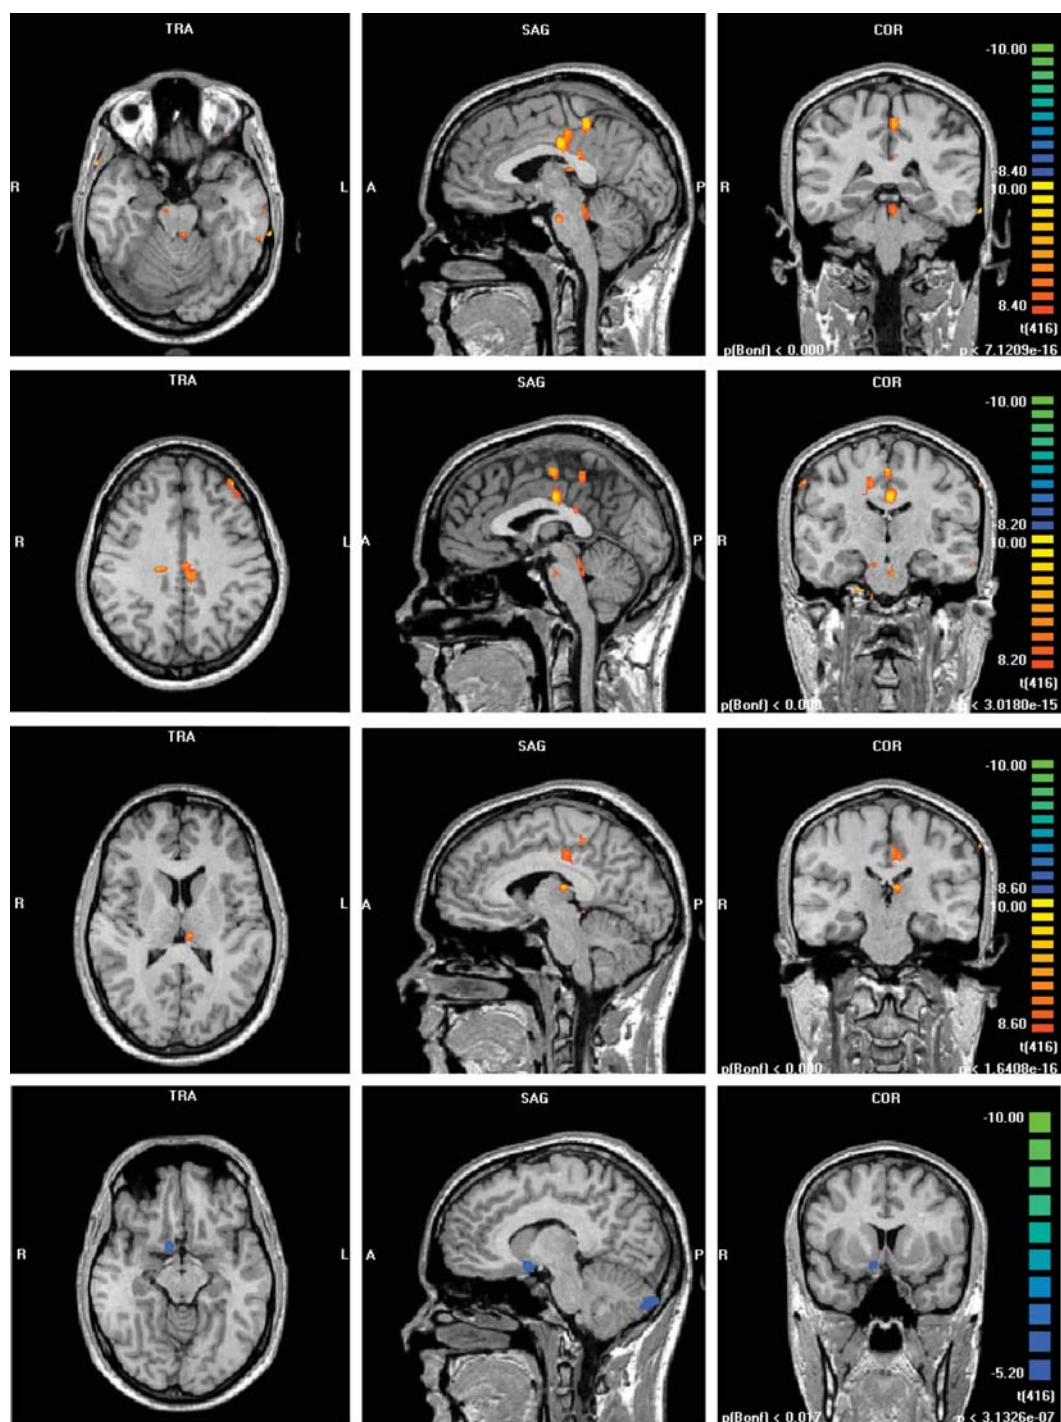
Functional MRI results of the GLM multistudy: merged display pattern of activations and deactivations. Activations are displayed in red to yellow; deactivations are displayed in blue to green. The left row shows axial slices, the middle row different sagittal slices and the right row coronal slices with activated areas in the GLM multistudy. The fourth horizontal row shows deactivations found in the GLM multistudy in axial, coronal and sagittal views.
